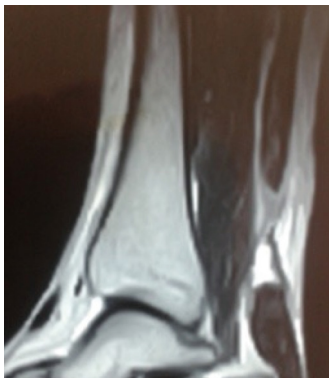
Pre operative MRI of one case.
